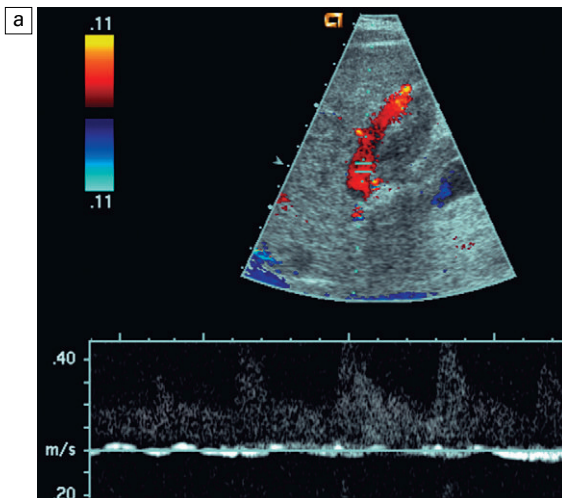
Spectral Doppler tracings of a patient with end-stage liver disease being considered for liver transplantation. (a) With neutral breath-hold, flow in this portal vein is barely perceived. It oscillates between hepatofugal during arterial systole and hepatopetal during arterial diastole. (b) When instructed to forcefully breathe in and out, this patient's portal flow became more dynamic. During forced expiration with elevated intrathoracic pressure there is increasing resistance to hepatic venous outflow forcing portal vein flow to become hepatofugal. During inspiration with negative intrathoracic pressure, this decreases the resistance to hepatic venous outflow thereby, causing flow to become almost stagnant.
